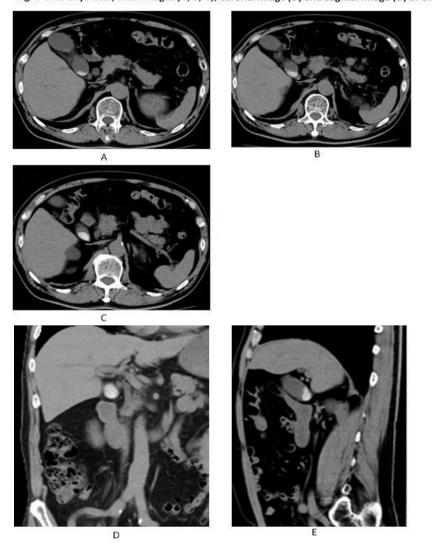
Five days later, axial images (A, B, C), coronal image (D) and sagittal image (D) of CT
